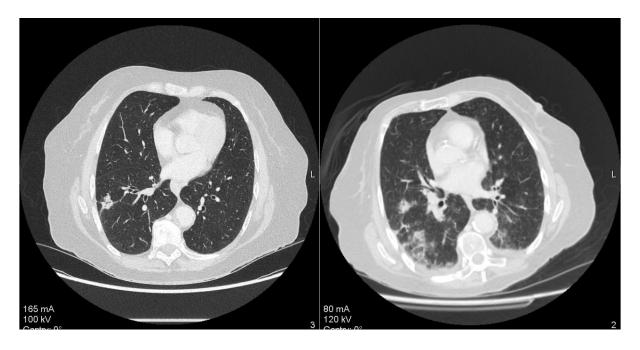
Subject RM-4644-003 axial CT images: (left) baseline i.e. pre-treatment showing 32 mm right lower lobe adenocarcinoma; (right) 1-month post SBRT and 1 cycle of nivolumab with evidence of bronchial infection and pneumonitis
